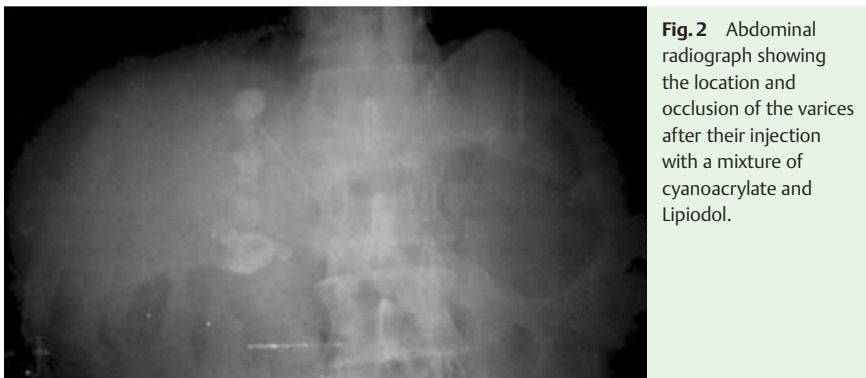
Abdominal radiograph showing the location and occlusion of the varices after their injection with a mixture of cyanoacrylate and Lipiodol.
